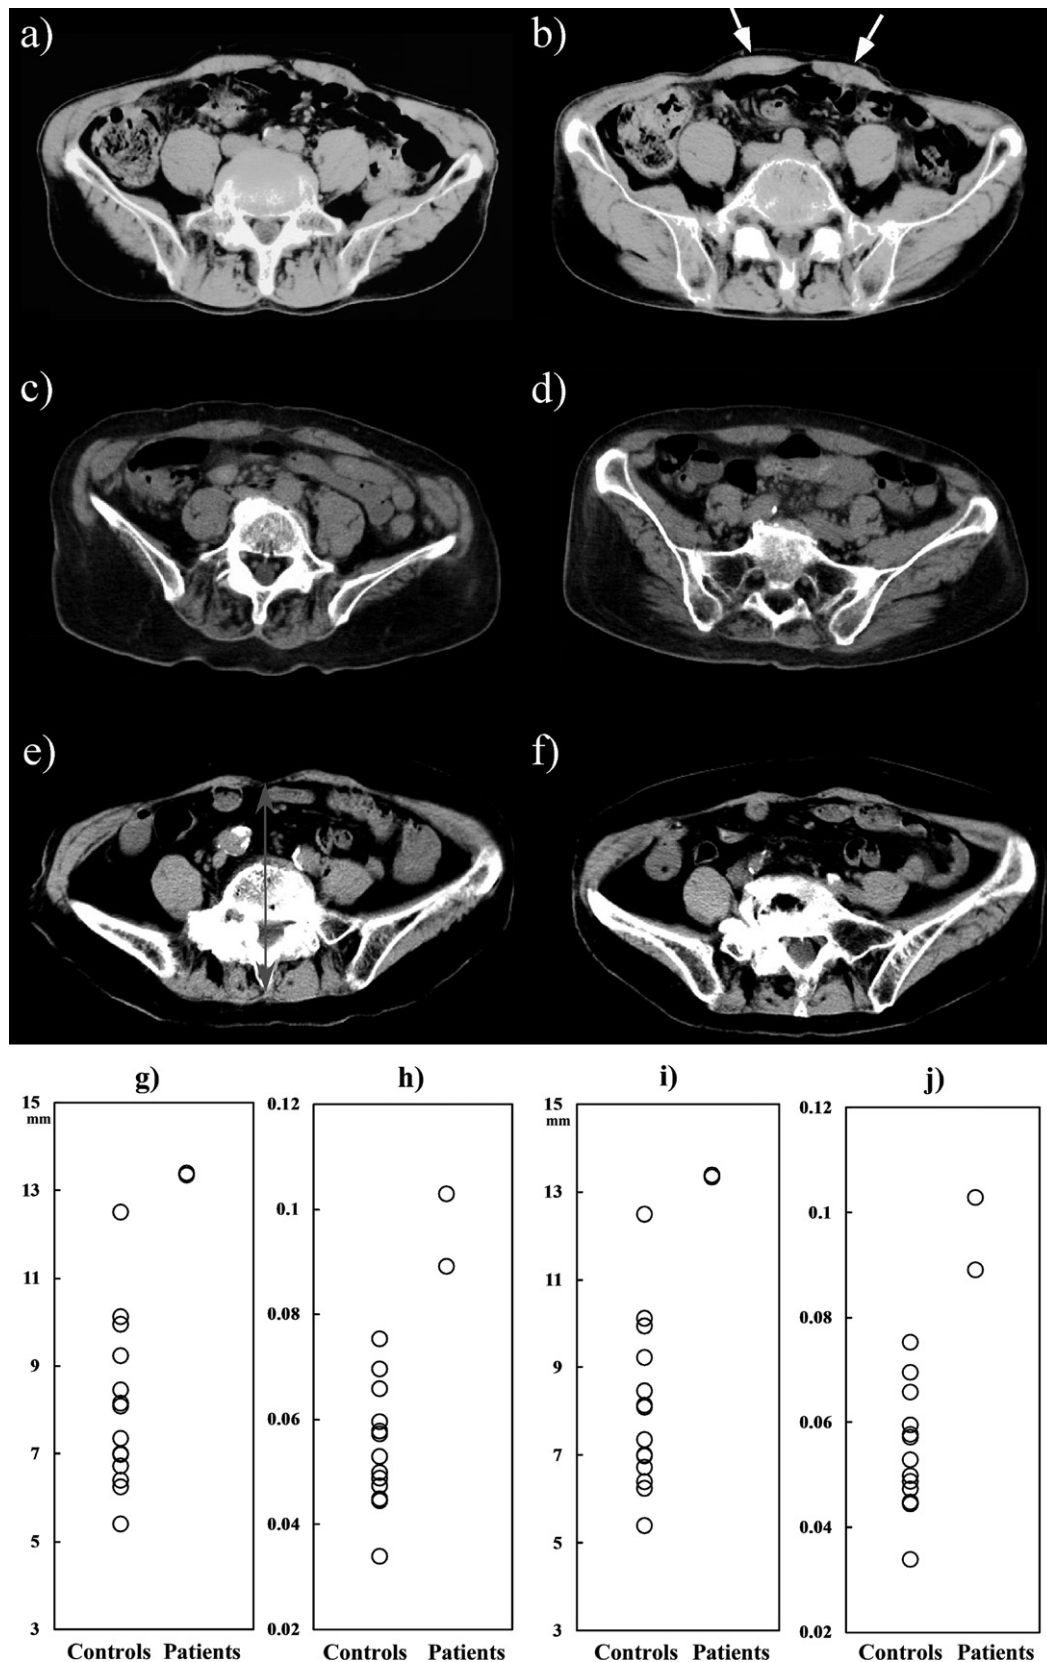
CT examination of the rectus abdominis muscle for thickness of the rectus abdominis and the relative muscle thickness ratio. Patients with Parkinson disease with painful abdominal contractions (a, b) Patient 1 and (c, d) Patient 2 showing muscle thickness of the rectus abdominis (white arrows in b) was greater than that of (e, f) control participants with PD. The right panels (i, j) were obtained at L4 and the left (g, h) at L5 vertebral level. The distance from the fascia between the left and right rectus abdominis muscles to the dorsal part of the vertebrae was calculated to derive the relative muscle thickness ratio (e, gray arrow). The thickness of the rectus abdominis (g) in Patient 1 and (i) in Patient 2 was greater than that of the control PD subjects. The relative muscle thickness ratio of (h) Patient 1 and (j) Patient 2 was higher than that of the control participants with PD.
